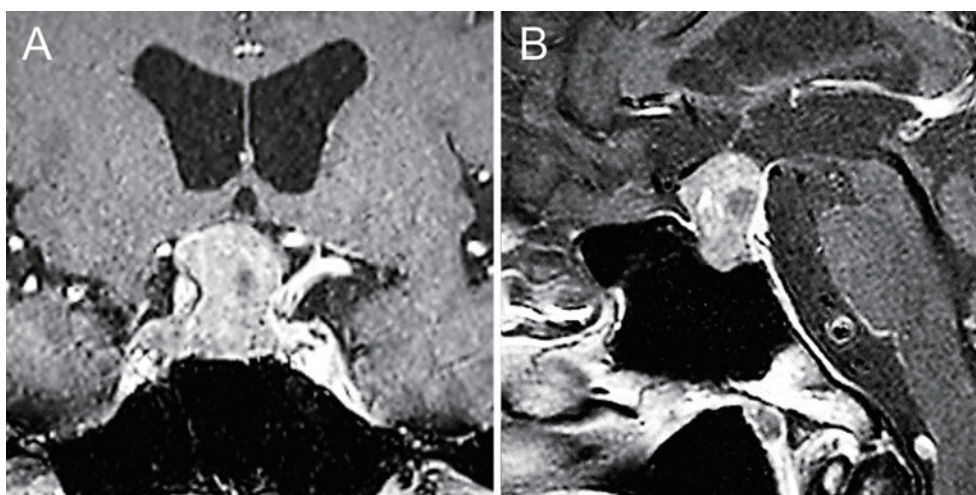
Preoperative coronal (A) and sagittal (B) contrast-enhanced T1-weighted magnetic resonance images showing heterogeneous enhancement of a pituitary tumor compressing the optic nerve and extending toward the anterior skull base.
